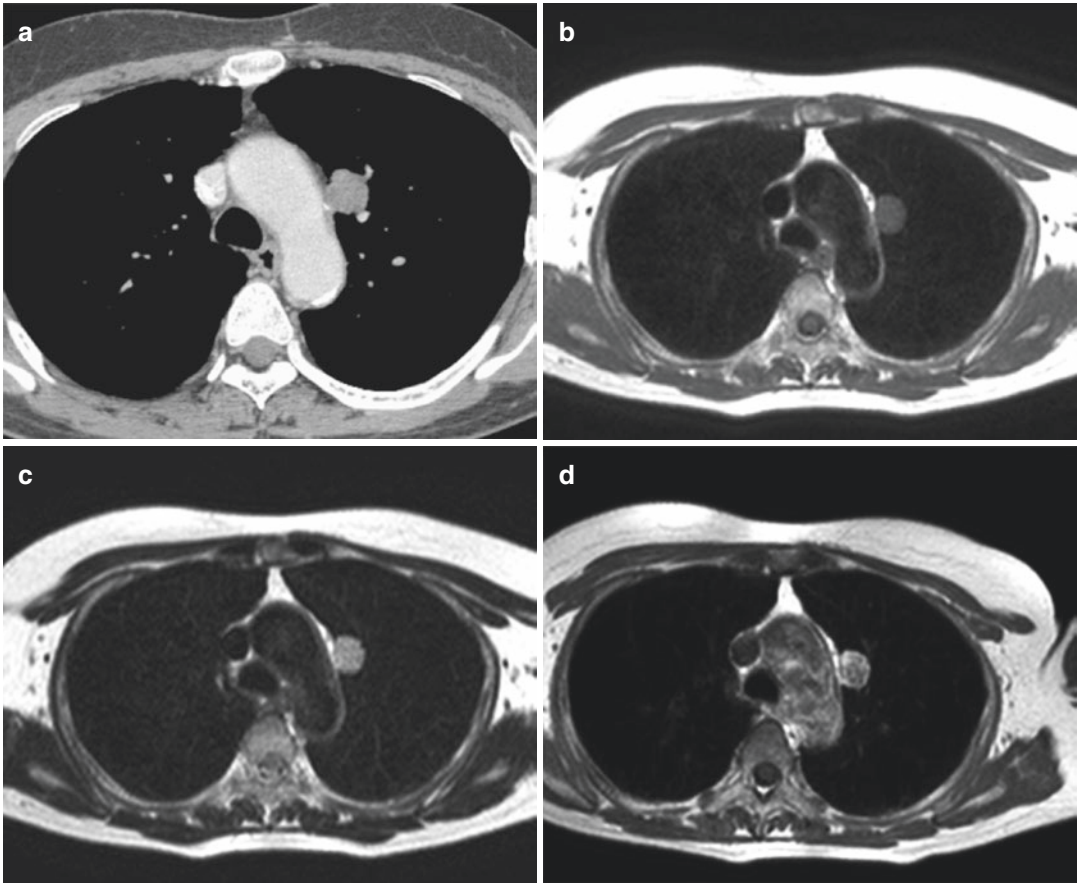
A 54-year-old male with hamartoma in the left upper lobe. Conventional contrast-enhanced CT shows lobulated nodule in the left upper lobe (a). Black-blood T1-weighted turbo SE (b) and T2-weighted (c) images show a lobulated nodule as, respectively, low and high
